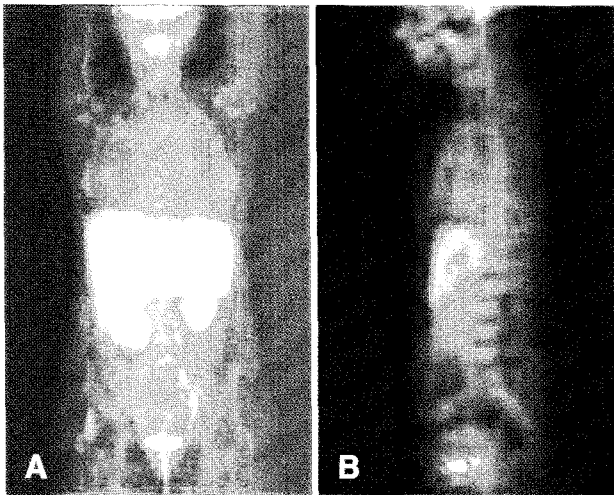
MIP images (A) of ^{18}F -FDG PET/CT showed hepatomegaly and diffuse increased ^{18}F -FDG uptake in the spleen and renal parenchyma. No significant focal hypermetabolic lesion suggesting malignancy was detected in the scan-covered area. Sagittal image (B) showed no significant abnormal hypermetabolic lesion suggesting malignancy.
